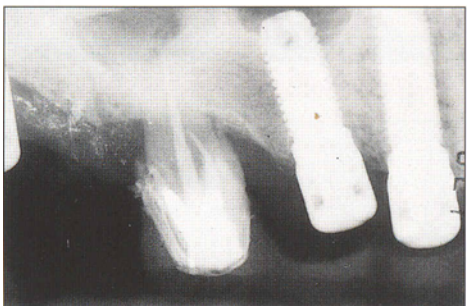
Stage 2 radiograph showing two implants in the place of the augmented sinus and extracted premolar and one tuberosity implant.
